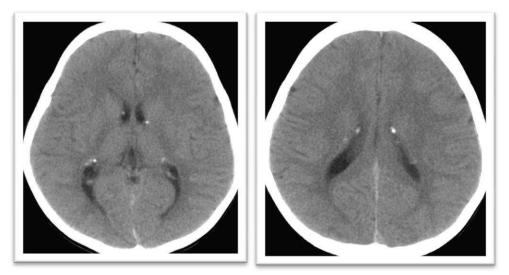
CT head: Multiple calcified subependymal tubers in both lateral ventricles.
